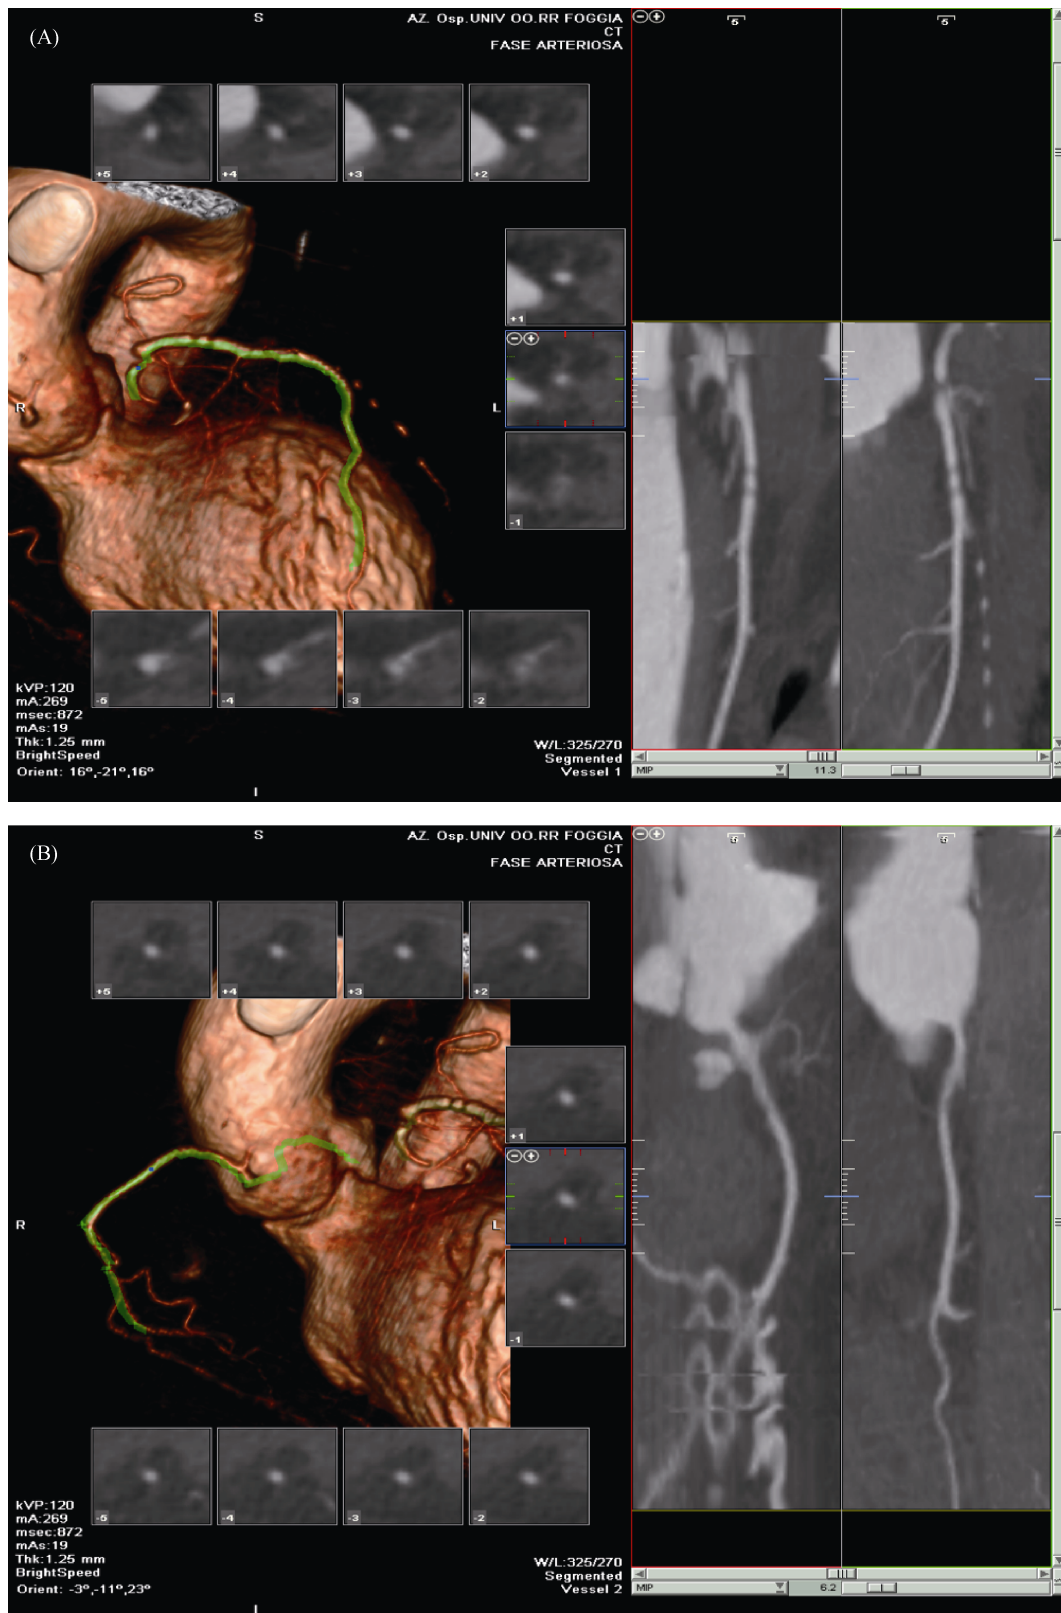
MPMCTA results of case No. 6. MIP reconstruction showed the calcified plaque at the left anterior descending coronary artery (A) and right coronary artery (B). Volume rendering reconstruction enabled a better visualization of the stenosis of the left anterior descending coronary artery and of the right coronary artery, respectively. MIP: maximum intensity projection; MPMCTA: multi-phase post-mortem CT-angiography.
